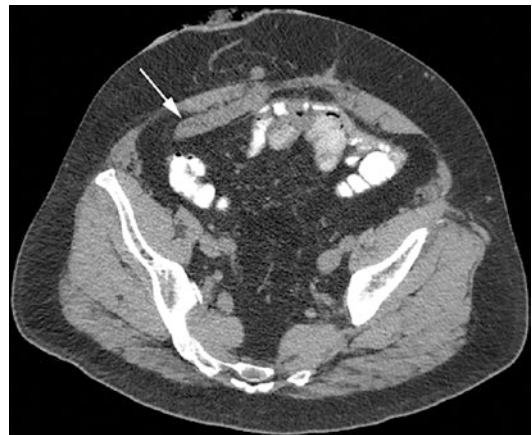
Axial CT imaging of a successful retromuscular Sugarbaker operation (Pauli Parastomal Hernia Repair) of an end ileostomy parastomal hernia. The lateralized bowel (arrow) can be seen entering a tunnel of mesh before traversing the rectus abdominis muscle and heading towards the mucocutaneous junction. The mesh is not visualized because of its reduced weight and lack of radiopaque fixation
